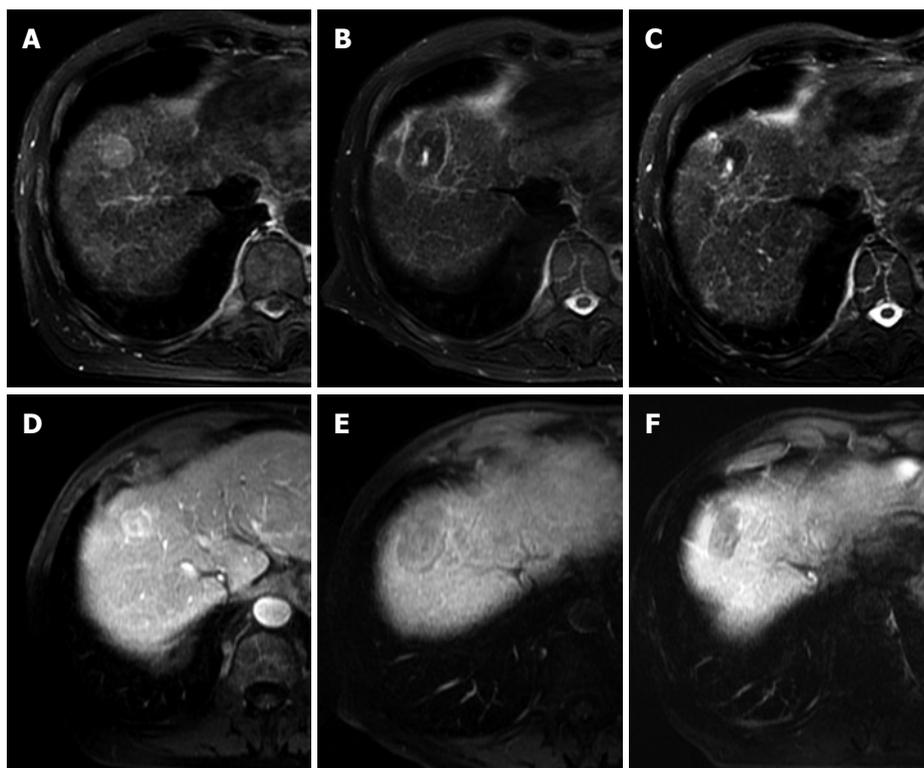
Typical MRI appearances pre and post laser ablation of a small HCC in a 73-year-old male patient with hepatitis C cirrhosis. T2-weighted axial images demonstrate a high signal 2.5 cm segment VIII HCC (A). At one month post treatment (B) a typical low signal laser burn is demonstrated with high signal centre which has shrunk in size at 10 mo follow up (C). T1-weighted post contrast images of the same lesion demonstrate heterogeneous arterial enhancement pre-treatment (D), with non-enhancing scar at 1 mo (E) and persistent non-enhancement at 10 mo (F).
